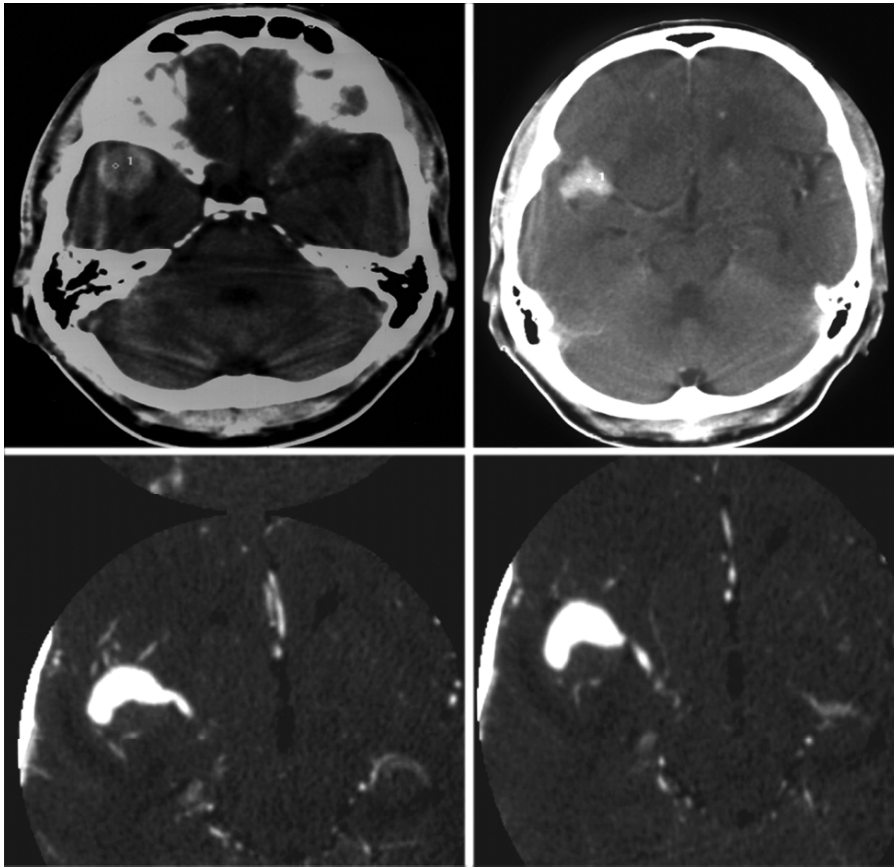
Computed tomography and computed tomography angiography—right Sylvian bleed due to right fusiform middle cerebral artery aneurysm
